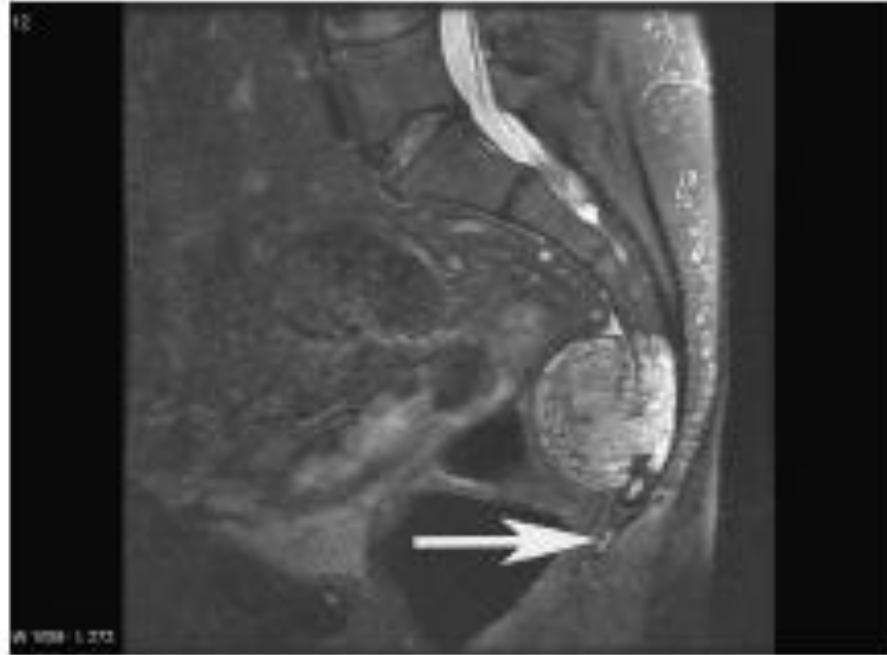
T2-weighted MR image demonstrating a high intensity for all lesions, including the cocygeal BNCT (white arrow).
